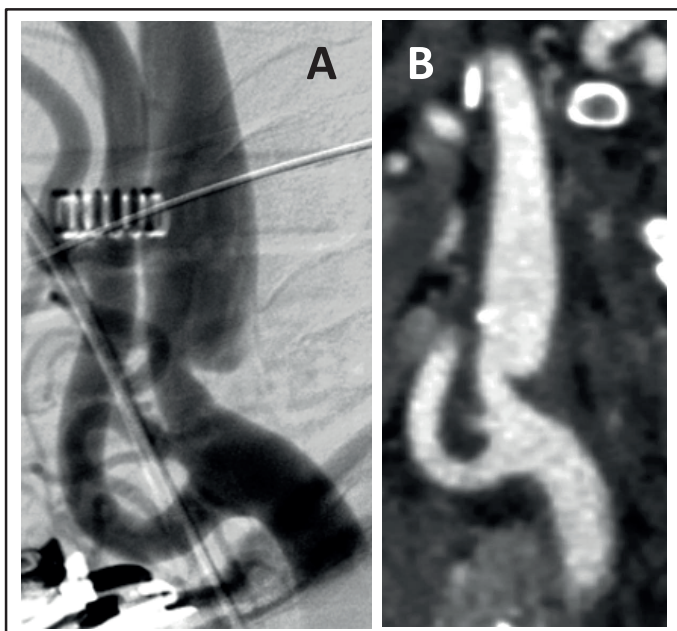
Digital subtraction angiography (A) and sagittal reconstruction of computed tomography angiography (B) demonstrating a carotid web in the carotid bifurcation.
